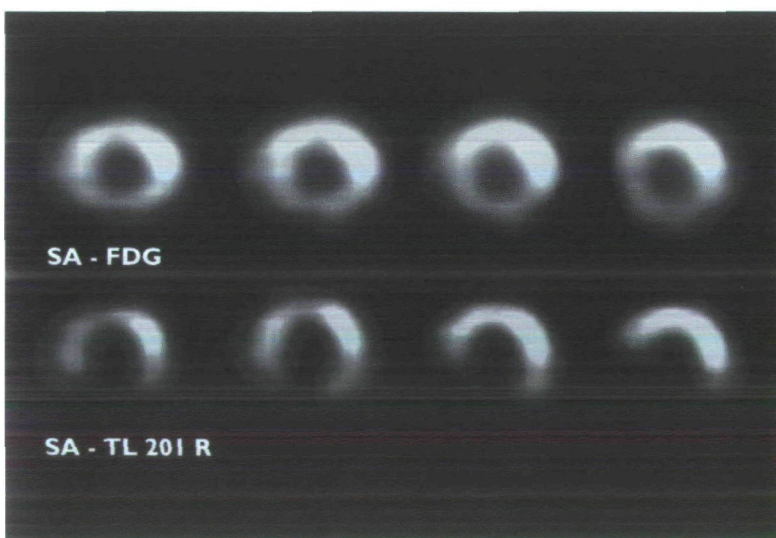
Corresponding series of short axis FDG (top) and thallium-201 (bottom) slices demonstrating a perfusion-metabolism mismatch in the infero-septal region.
